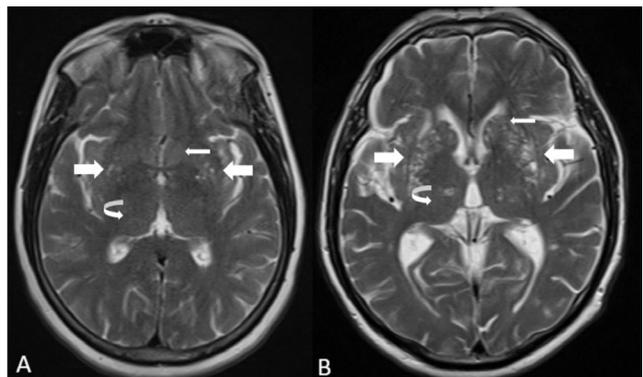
Axial T2W MR images at level of basal ganglia showed A); grade 1 BGPVS (thick arrows), head of caudate nucleus (thin arrow), thalamus (curved arrow). B); grade 4 BGPVS (thick arrows), head of caudate nucleus (thin arrow), thalamus (curved arrow)
